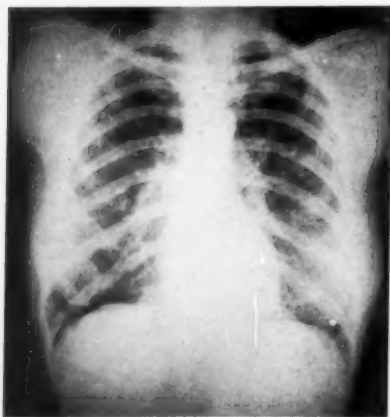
Case 9. Postero-anterior X-ray. Cyst of accessory lobe of the right lung. The edge of the cyst is just visible in the third right intercostal space.
